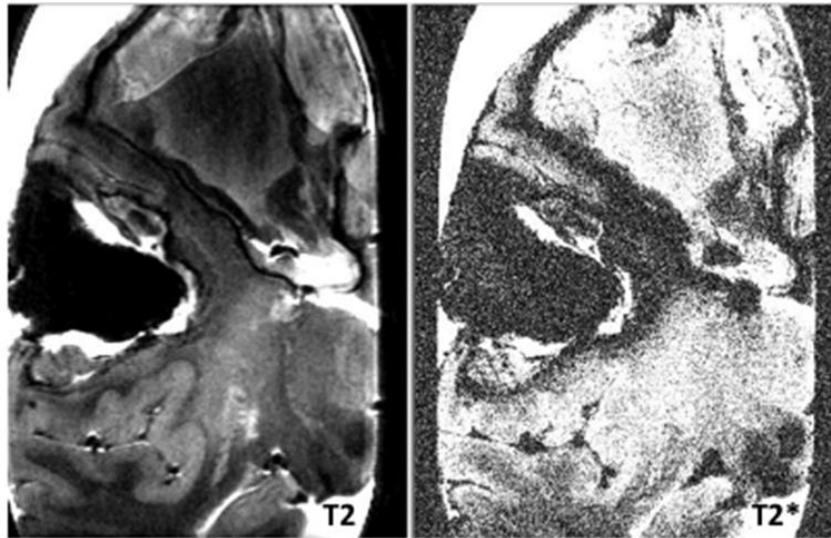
Post-mortem T2 and T2* 7.0-tesla MRI imaging of a coronal section of a cerebral hemisphere with two lobar haematomas: a hyperacute one with a homogenous hypo-intense core and a one month old one with only hypo-intensities in the boundaries.
